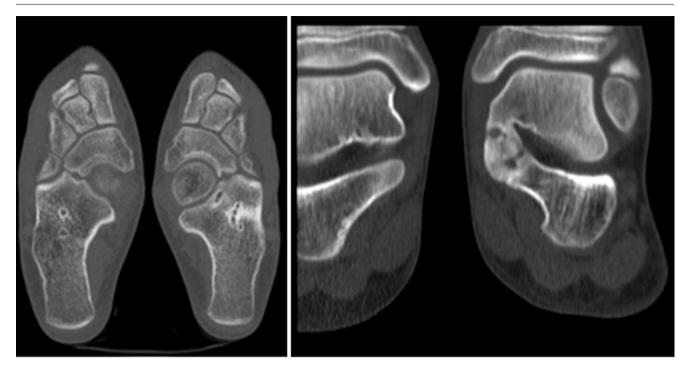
CT scan showing bilateral calcaneonavicular tarsal coalition (*left*) and right talocalcaneal tarsal coalition (*left*)
